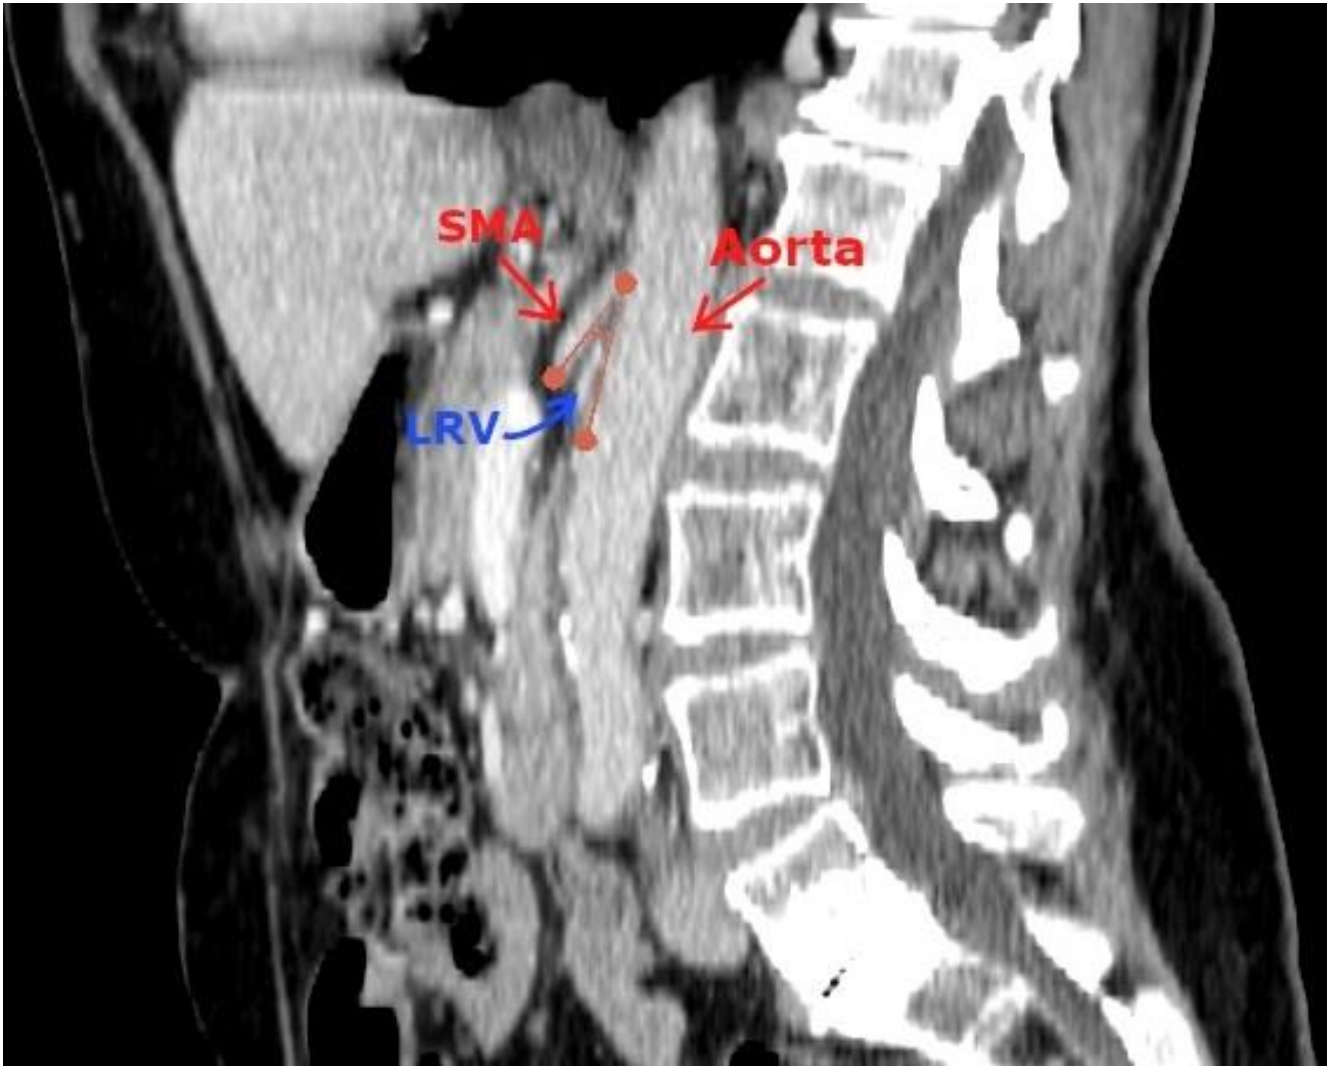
CT sagittal plane. The structures are labeled as follows: "LRV"-Left Renal Vein, "SMA" – Superior Mesenteric Artery. This image marks the angle between the aorta and the Superior Mesenteric Artery (indicated in pink; the angle is approximately 22.8°).
